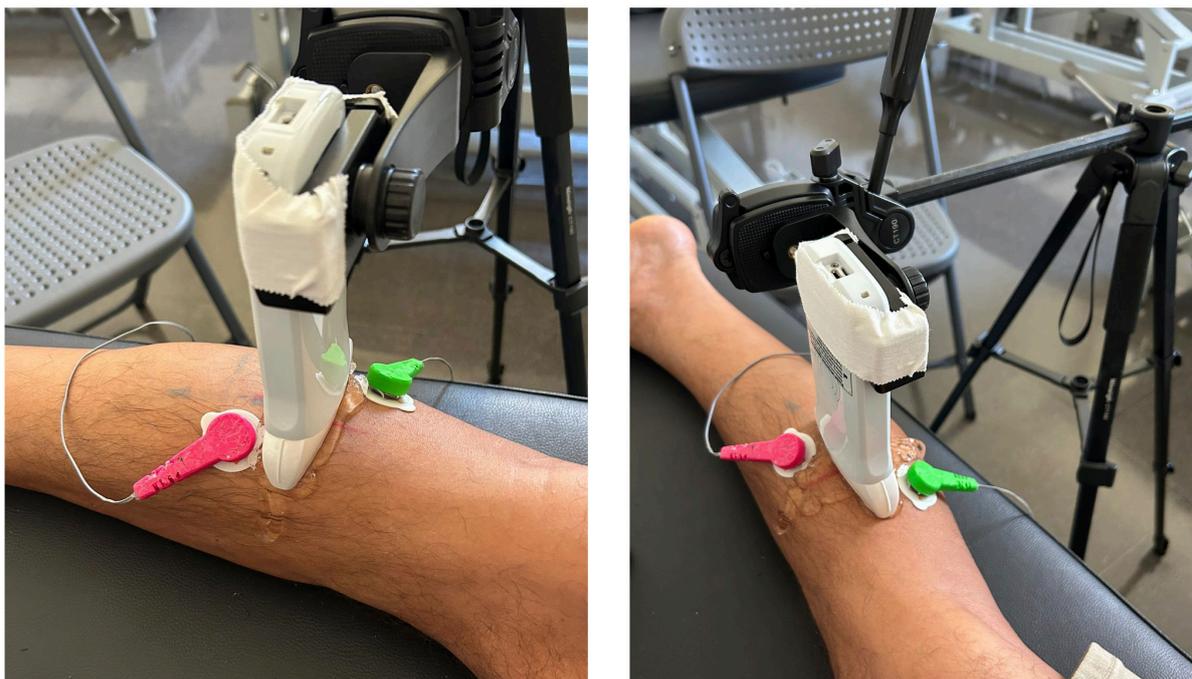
Oblique placement of electrodes with the ultrasound probe in transverse (Figure 5A) and longitudinal (Figure 5B) planes.
